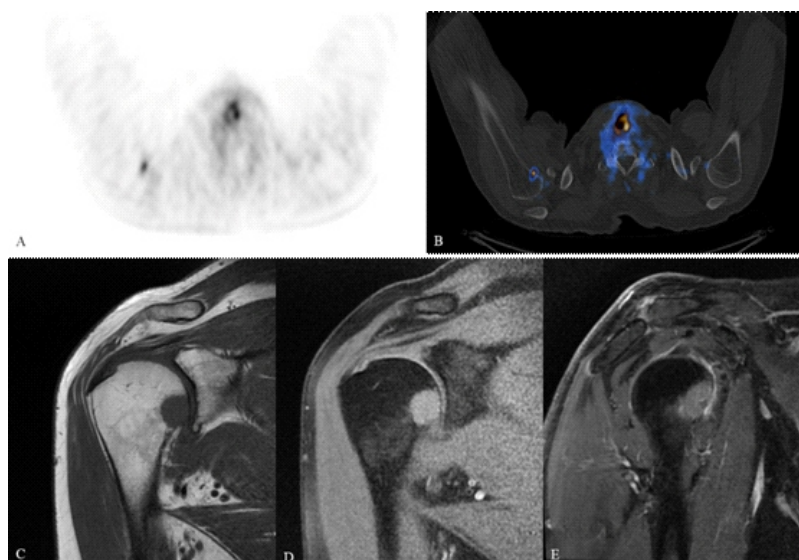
Patient with locally advanced prostate cancer diagnosed in 2015 and treated with androgen deprivation therapy (ADT). Subsequent brachytherapy in 07/2016 due to unwanted side effects of ADT. Patient was referred for an ^{18}F -PSMA-1007 PET/CT examination in 06/2018 due to minor increase of his PSA value (0.3ng/mL) and negative conventional imaging (CT, bone scintigraphy and Prostate-MRI; not shown). A moderate/equivocal PSMA uptake in the humeral head right (A: axial cross section PET, B: fused axial PET/CT image) without morphological correlative in the CT examination was judged as unspecific from the referring physician and watchful waiting was carried out. Unfortunately, 3 months later PSA value rose to 8.1 and 15.2ng/mL by 01/2019 without findings in the conventional examinations (CT, bone scintigraphy and Prostate-MRI; not shown). The PET/CT images were re-assessed, and an MRI of the right humeral head was then performed confirming the presence of an osseous spread (B-E).
